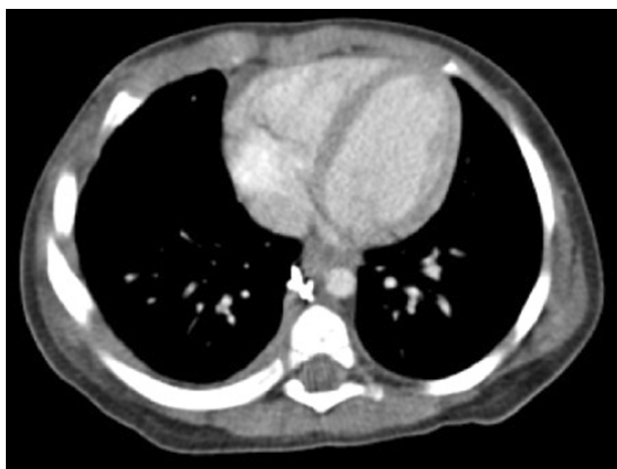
Follow-up chest CT scan showed resolution of the enhancing lesion.
